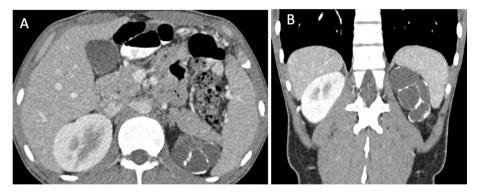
Pelvicalyceal tuberculosis in a patient with known miliary tuberculosis. Contrast-enhanced CT demonstrates diffuse caliectasis with extensive thinning and calcification of the left renal parenchyma.
